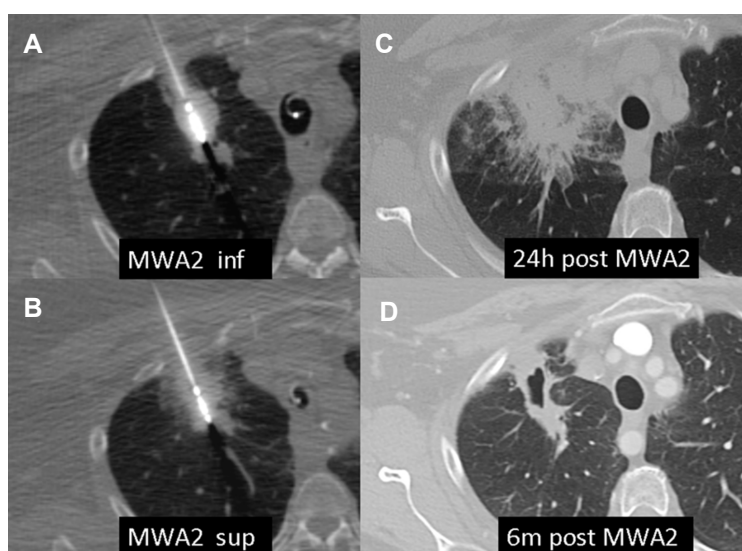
57-year-old female with right upper lobe squamous cell carcinoma. A, B: Repeat microwave ablation, 2 overlapping ablation cycles; C: axial CT 24 h post re-ablation shows circumferential ground-glass opacity of at least 1 cm; D: axial CT 6 months post re-ablation shows significant shrinking of ablation site with central cavitation
